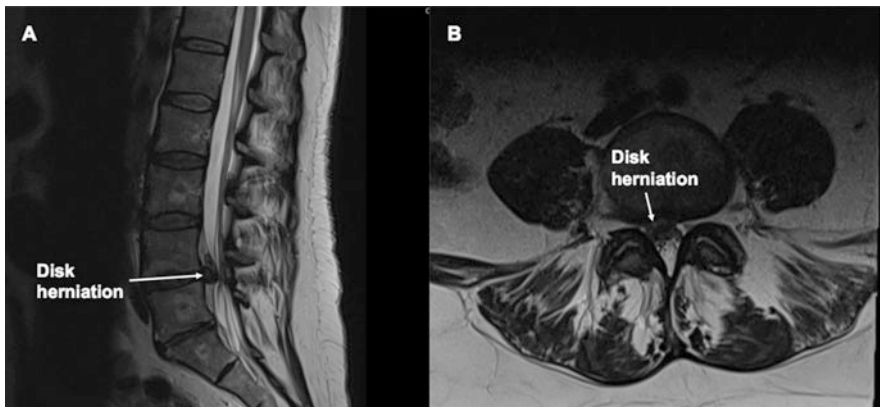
Right-sided disk herniation causing compression of spinal canal and cauda equina nerve roots. (a) Sagittal T2-weighted MRI demonstrating compression of spinal canal and nerve roots. Swelling of nerve roots is noted
